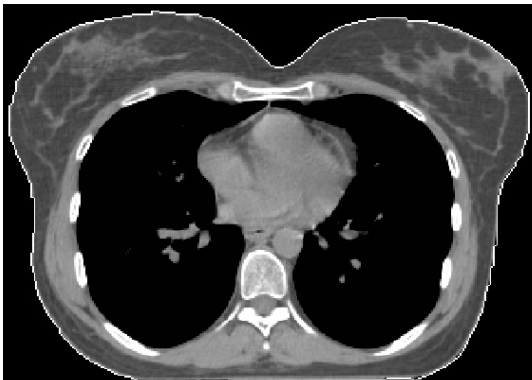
Axial computed tomography images of the patient showing complete resolution of bilateral breast lesions after breathing adapted radiation therapy.
